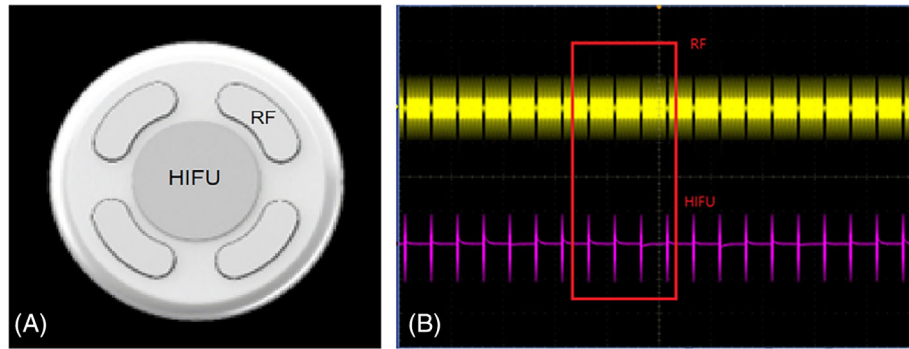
A high-intensity focused ultrasound device that combines RF irradiation into a circular probe with a 2.5 cm diameter. (A) The Simultaneous Dual (SD) probe of the device. Ultrasound is emitted as a single dot from the center of the handpiece, and RF energy is emitted from the edges. (B) When bipolar RF is irradiated with a 2 MHz frequency and an 80 ms pulse duration, HIFU is alternatively irradiated using a frequency of 7 Hz.
